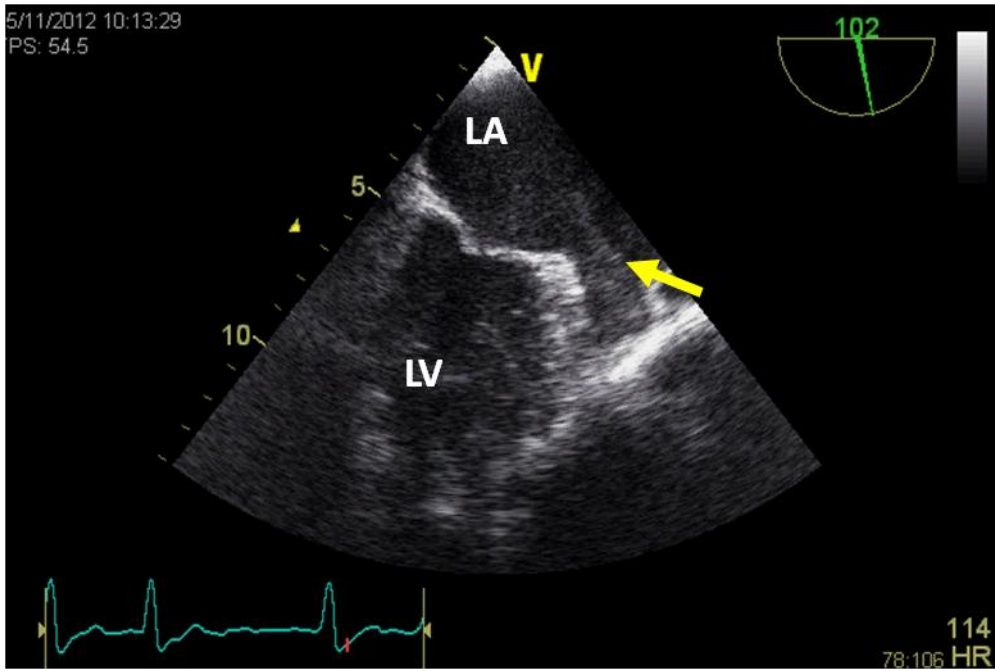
Dense SEC (yellow arrow) with swirling movements in the left atrium (LA) and left atrial appendage can be seen in this transesophageal echocardiographic image. LV, Left ventricle.
